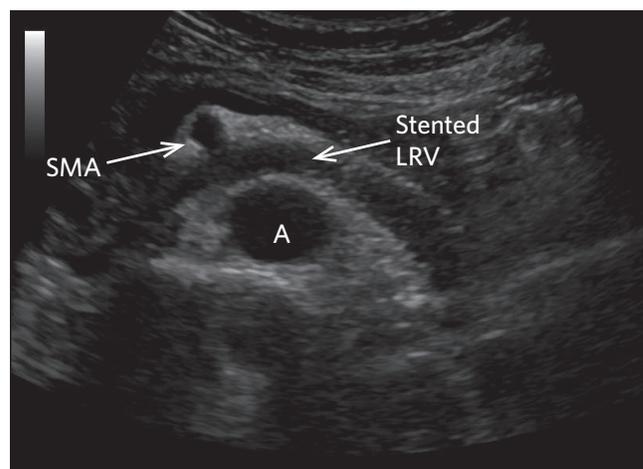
Duplex ultrasound showing a patent renal stent. Left renal vein (LRV) between the aorta (A) and superior mesenteric artery (SMA).
